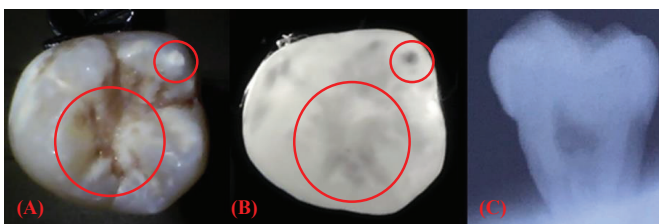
Sample 1 under visible light (A), NIR light (B), and X-rays (C).
